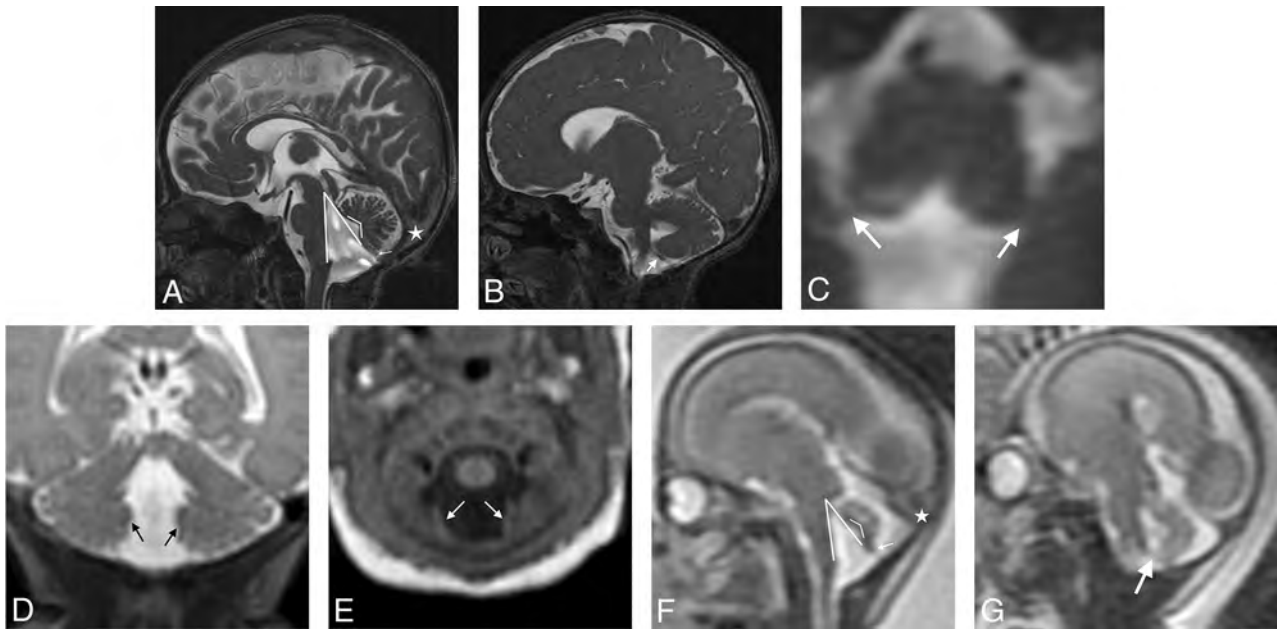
Dandy-Walker phenotype: MR imaging criteria. Balanced steady-state sequence (0.8-mm section thickness, 0.4-mm section spacing) in the sagittal (A), parasagittal (B), and axial (C) planes and coronal T2WI (1-mm section thickness, 0-mm section spacing, D) and axial T1WI (1-mm section thickness, 0-mm section spacing, E) from a neonate show inferior predominant VH, an enlarged tegmentovermian angle at 35° (*thick-lined angle, A*), an obtuse fastigial angle at 119° (*thin-lined angle, A*), an unpaired caudal lobe (ie, tail-sign; *thin arrow, A*), and inferolateral displacement of the taenia-tela choroidea complex and choroid plexus distant from the vermis (*thick arrows, B–E*). Similar findings are seen in the same patient on fetal MR imaging at 22 weeks' gestational age in sagittal (F) and parasagittal single-shot T2WI (3-mm section thickness, 0-mm section spacing, G). Note a normal torcular position (*stars*); the torcular position is variable in all forms of posterior fossa abnormalities/anomalies and should not be considered in isolation as an interpretive criterion in the differential diagnosis.
